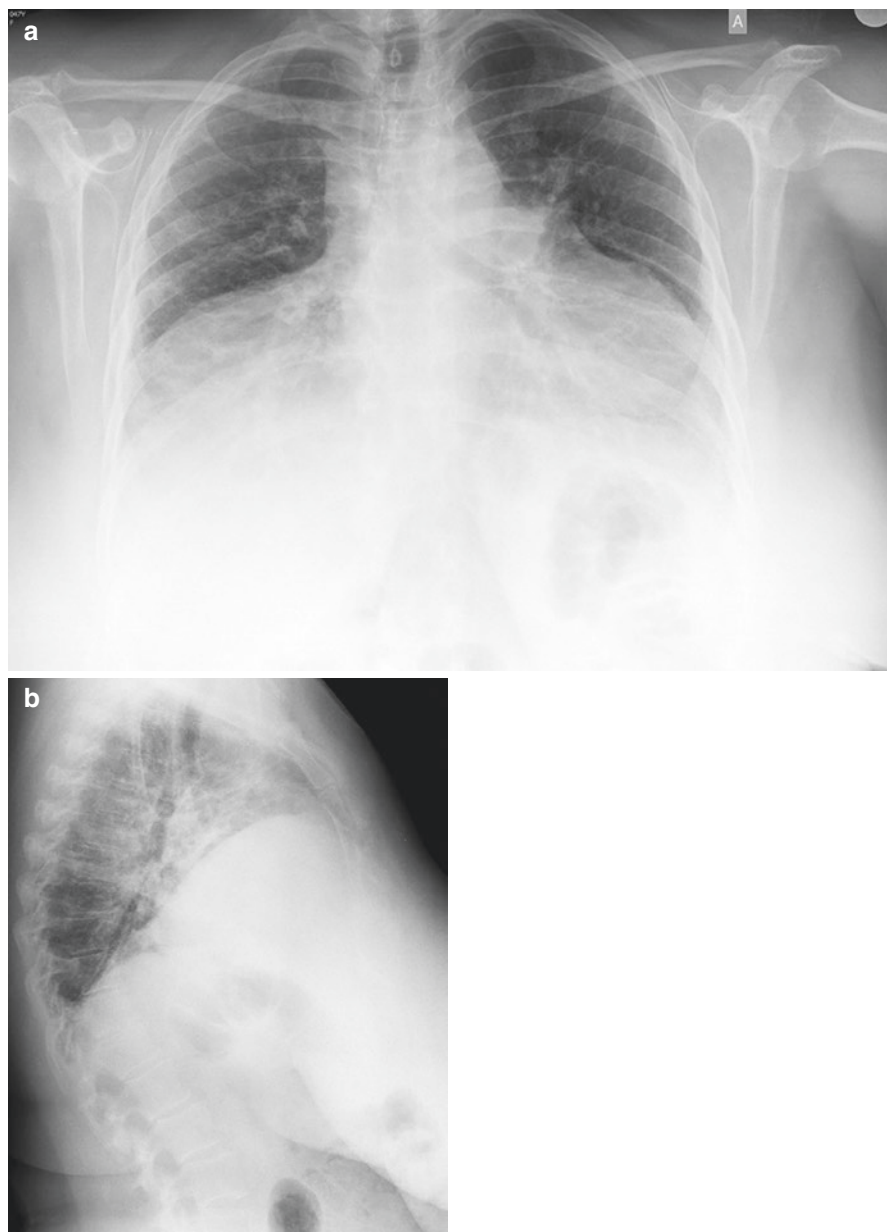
Polymyositis – lung involvement (plain radiography)
